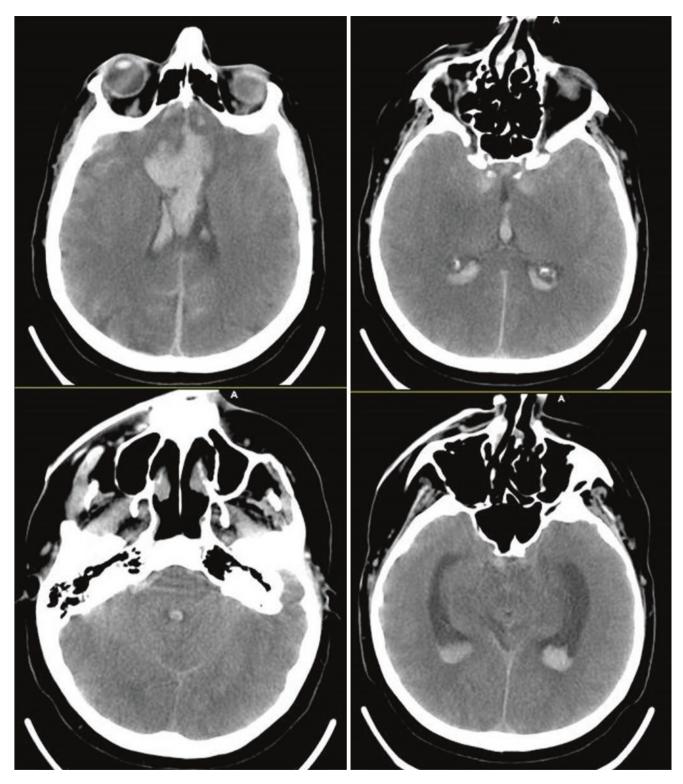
Computed tomography scan upon admission
